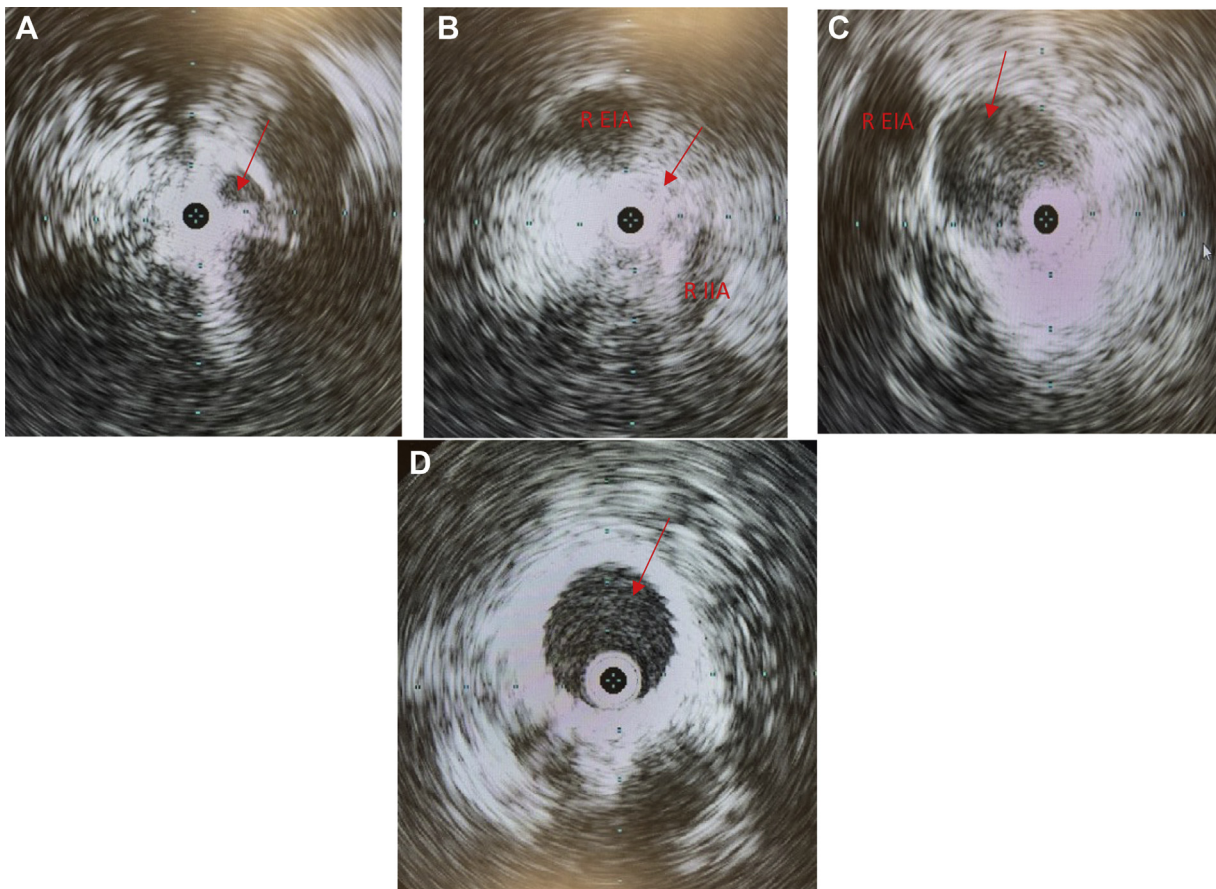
Intravascular ultrasound (IVUS) images: (A) preintervention compressed lumen of the right common iliac vein; (B) totally compressed distal right common iliac proximal external iliac veins; (C) normal caliber of the right external iliac vein; (D) poststenting of the iliac vein. *R EIA*, Right external iliac artery; *R IIA*, right internal iliac artery.
